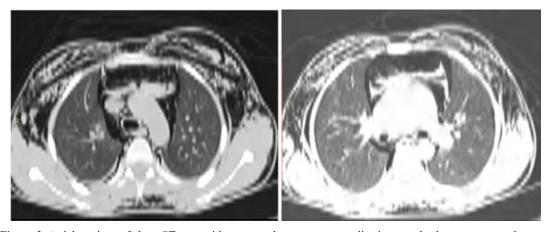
Axial sections of chest CT-scan with contrast shows pneumomediastinum and subcutaneous emphysema
